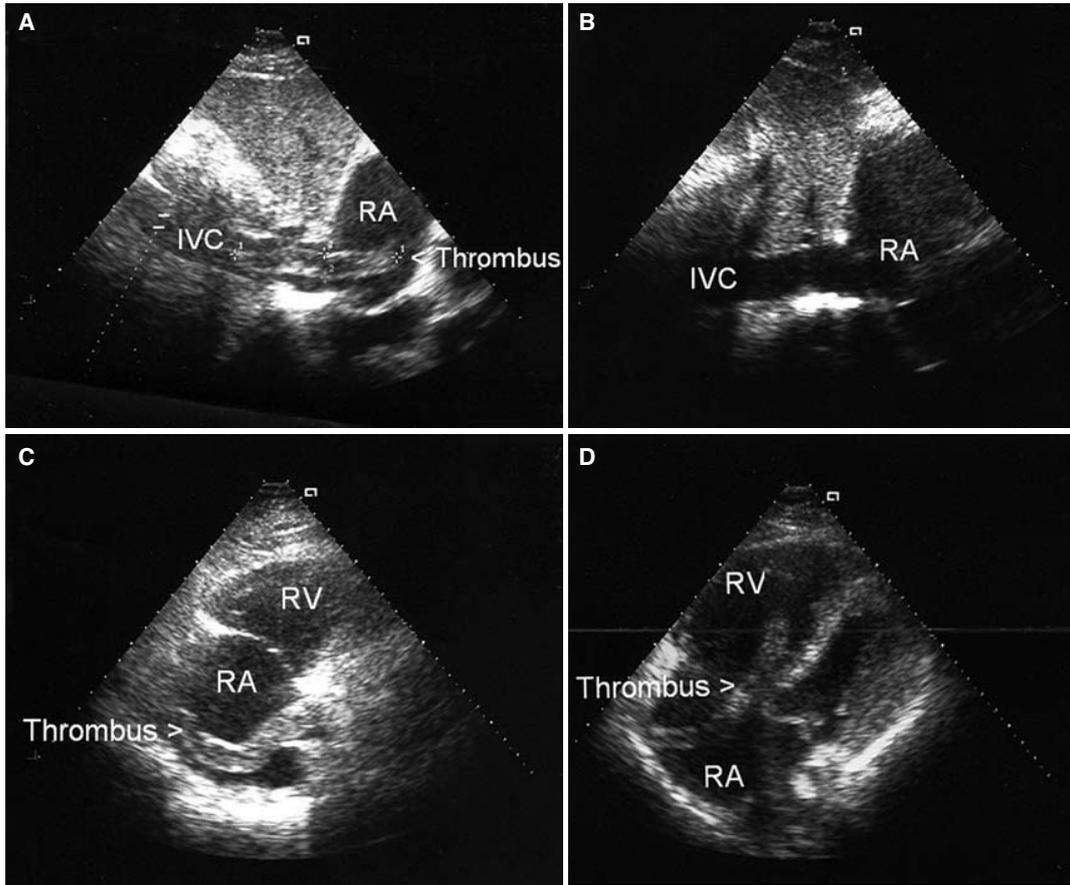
(A) Transthoracic echocardiogram: subcostal view of the giant worm-like thrombus in the inferior vena cava (IVC) with its proximal portion protruding into the right atrium (RA). (B) Subcostal view showing empty inferior vena cava after the migration of the thrombus into the RA. (C) Modified apical four-chamber view demonstrating the thrombus entrapped in the RA. (D) Apical four-chamber view showing protrusion of the thrombus into the right ventricle (RV).
